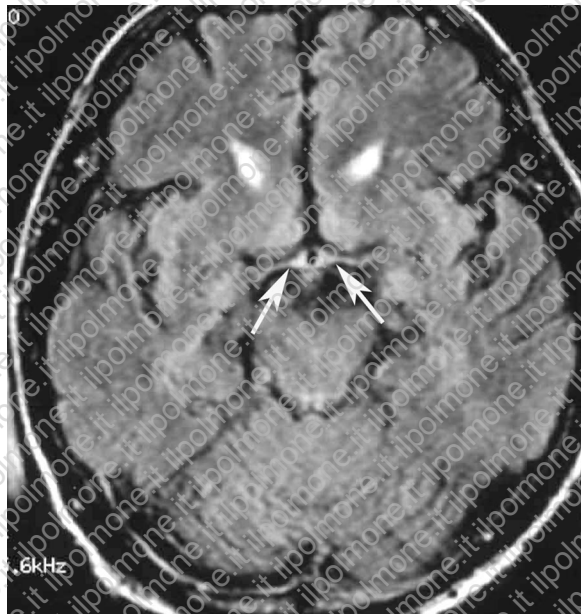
Neurosarcoidosis. On a FLAIR MR image obtained in the same patient as in Figure 13, the optic chiasm demonstrates increased signal intensity (arrows).
